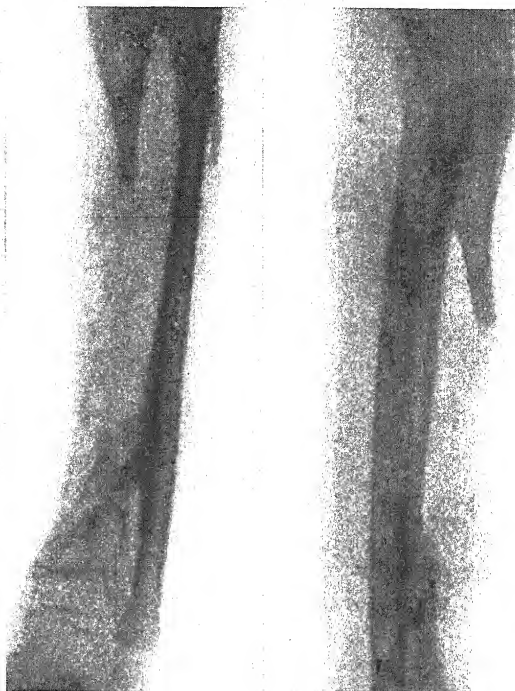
X-ray two months after the grafting operation.
